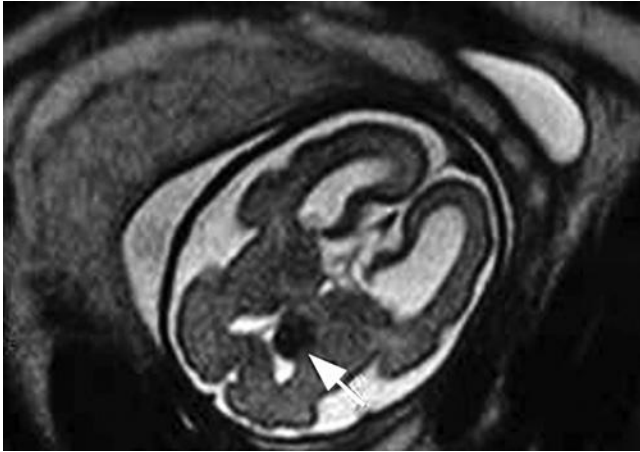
Axial view (T2-weighted) in a fetus of 26 weeks' gestation showing a typical subependymal nodule (arrow). (Courtesy of Heron Werner, 2005. Available at thefetus.net.)
